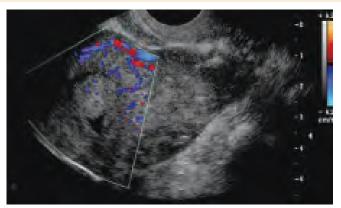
Focal endometrial thickening demonstrated by color Doppler ultrasound
